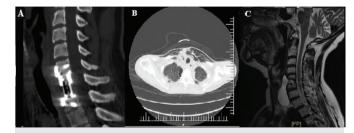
Sagittal computed tomography (CT) image following the development of C6 corpectomy (A), axial thoracic CT showing the development of mediastinitis (B), sagittal T2-weighted magnetic resonance imaging image showing the development of cerebrospinal fluid fistula (C)
